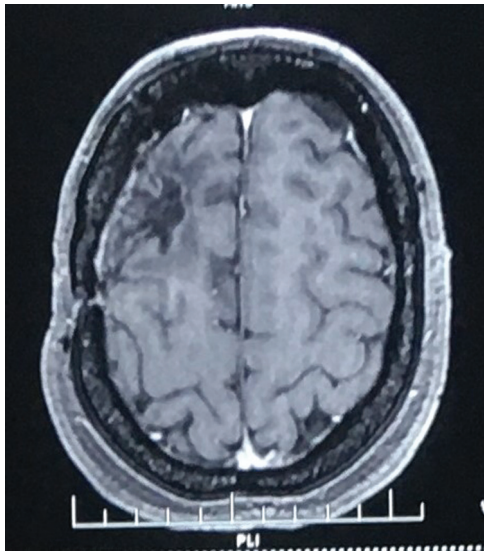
Axial contrast magnetic resonance imaging brain taken 8 months after surgery showing gliotic changes in right frontal lobe.
